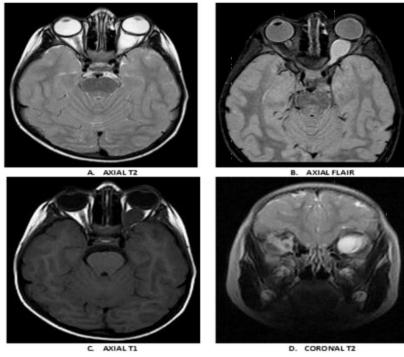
Showing MR images of a case with glioma
